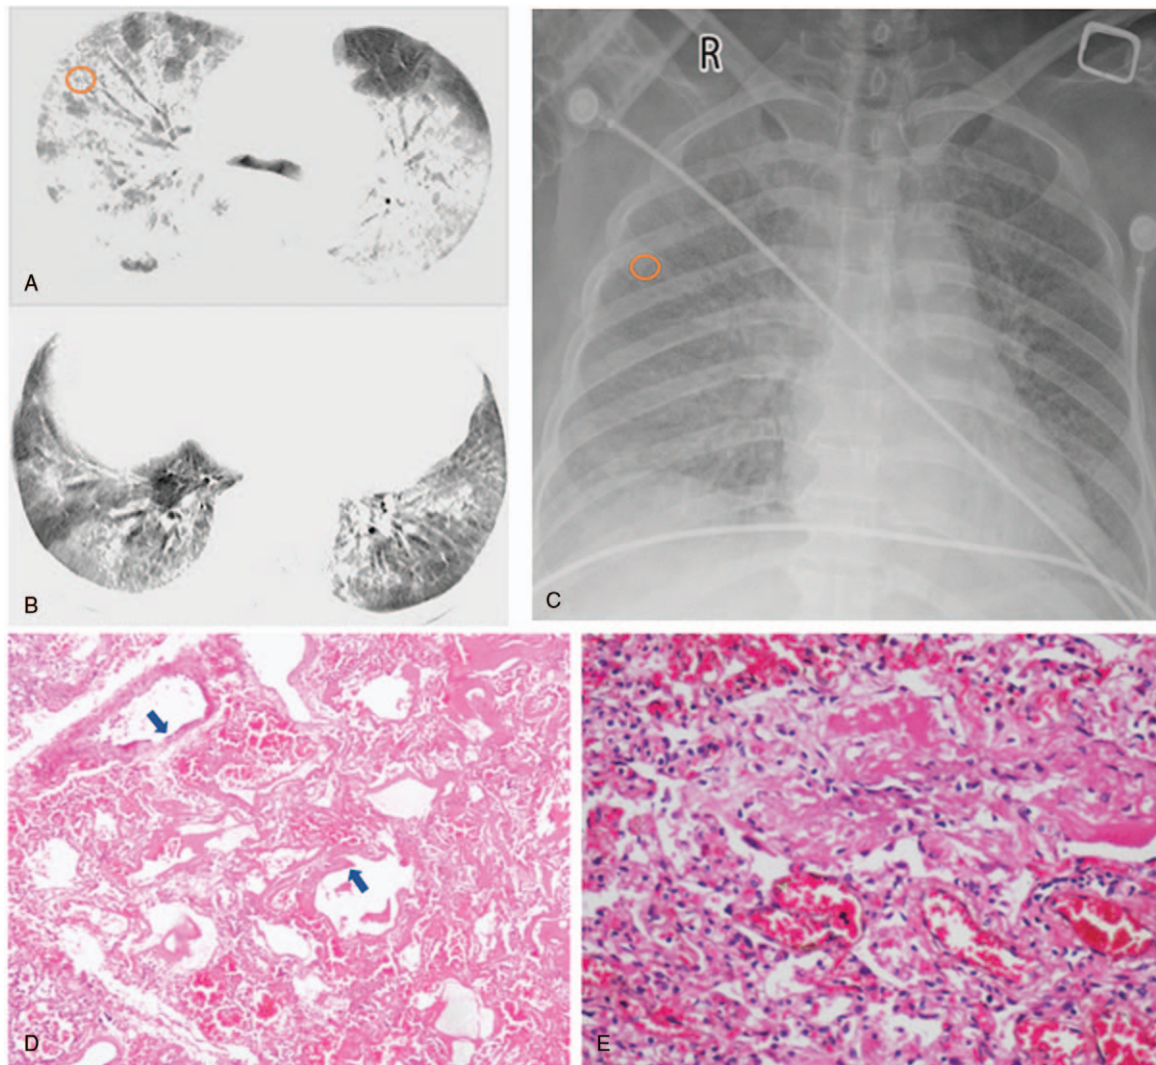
A-B: Large-scale patchy ground-glass opacities with consolidation and interstitial thickening was observed (the 5th day from onset), presenting as “white lungs” in radiographic images. C: The 10th day from onset. D: Exudative phase of diffuse alveolar damage showing hyaline membrane formation (arrows), serous and fibrinous exudate, pulmonary congestion and edema, and small amounts of inflammatory cell infiltration in the right upper lobe ($\times 100$). E: Pulmonary congestion, hemorrhaging, exudate organization in alveolar spaces, and fibrosis of the alveolar septa. Thickened alveolar walls and widened interstitial tissues were accompanied by lymphocytes and other inflammatory cell infiltration and fibroblast proliferation in the right upper lobe ($\times 100$). Yellow circles in figures represent pathological sampling sites.
